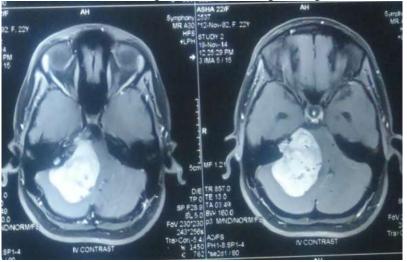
MRI Axial section showing midline cerebellar SOL
